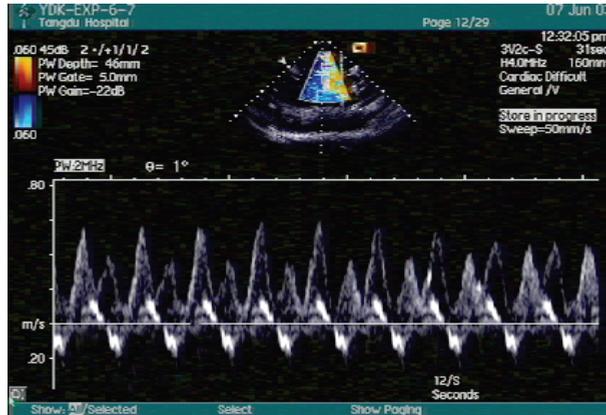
Doppler signals generated by fluid and tubing motions. The frequency of the motion of the tubing and the frequency of the peristaltic pump were varied. The frequencies of two motions were very close, but desynchronized. The relative magnitude of the measured signals during the cycle varies even though the actual frequencies and velocities of motion and flow were constant. The two motions may have various phase combinations, yielding different modified Doppler flow velocity spectra
